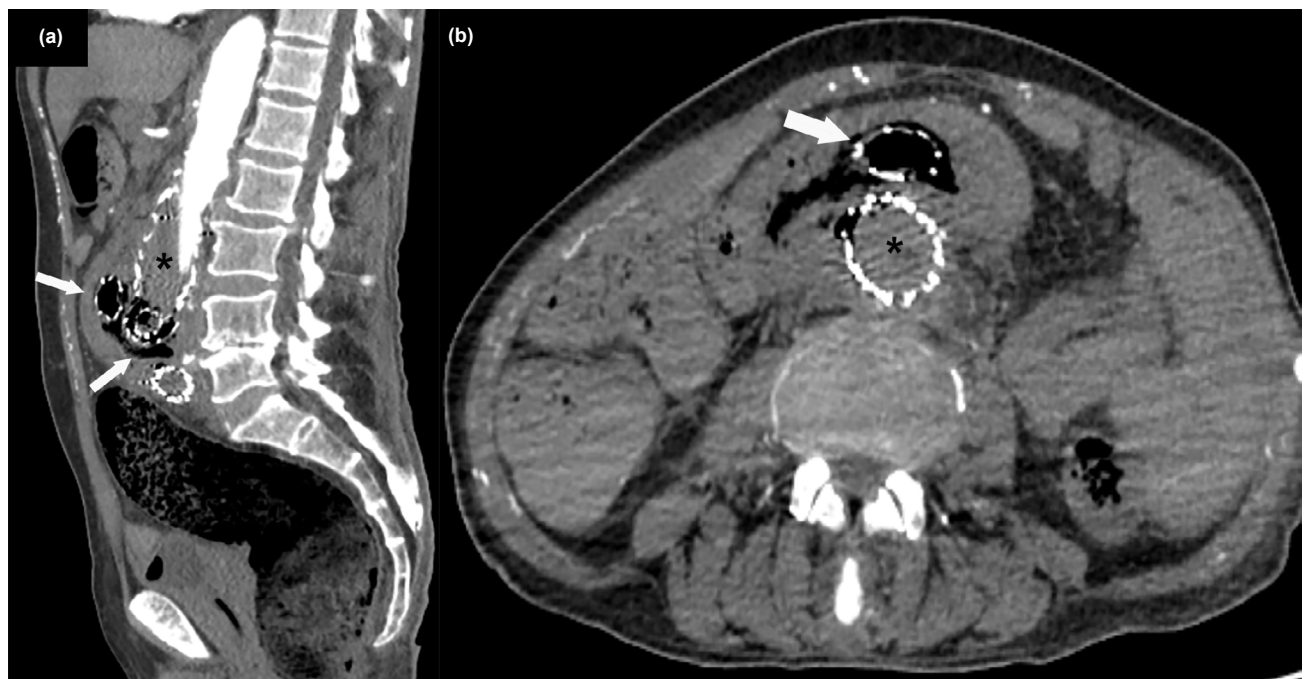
Sagittal (a) and axial (b) computed tomography (CT) angiography images obtained at the level of the duodenum and aorta show the aortic endograft filled with air and coursing into the duodenal lumen (white arrows in a and b). Note the total occlusion of the aorta at the level of the stomach (black asterisks in a and b).
